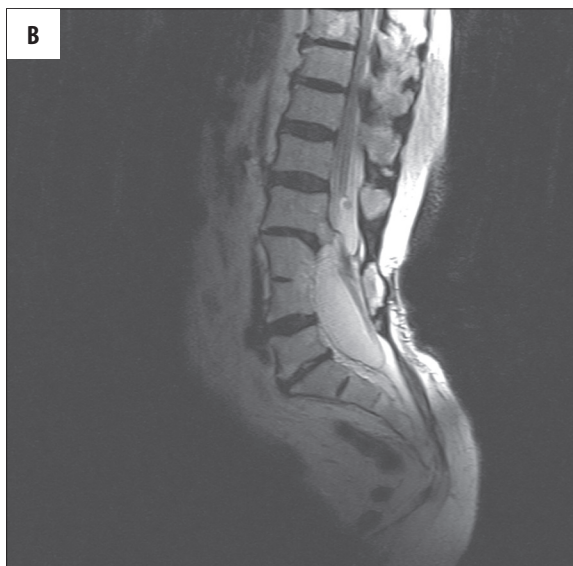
MR image in sagittal plane: T1-weighted image (A), T2-weighted image (B), PD-weighted image (C). Partial fusion of vertebra L3–L4, an osseocartilaginous septum on the L2–L5 level. On the L2 level, there is a round structure, possibly corresponding to an epidermoid cyst.
